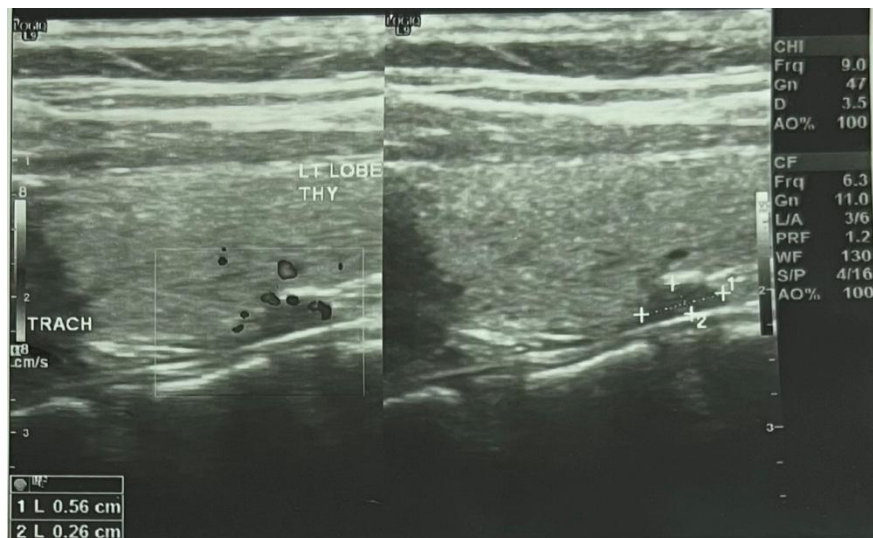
Neck (thyroid) ultrasound, left lobe
